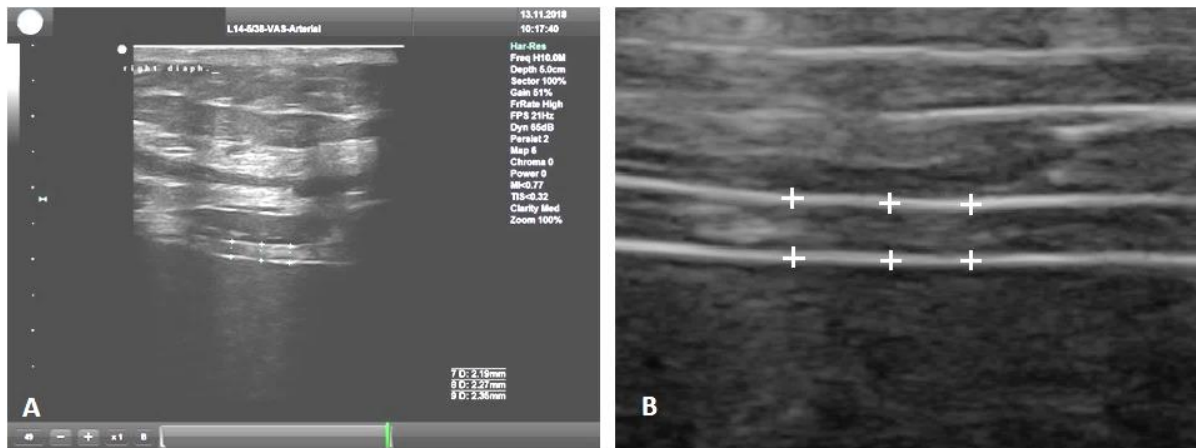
Ultrasound measurement of right side diaphragm, linear probe, 10 MHz (a), measurement is made from the middle of the pleural line to the middle of the peritoneal line (b) in detail.
